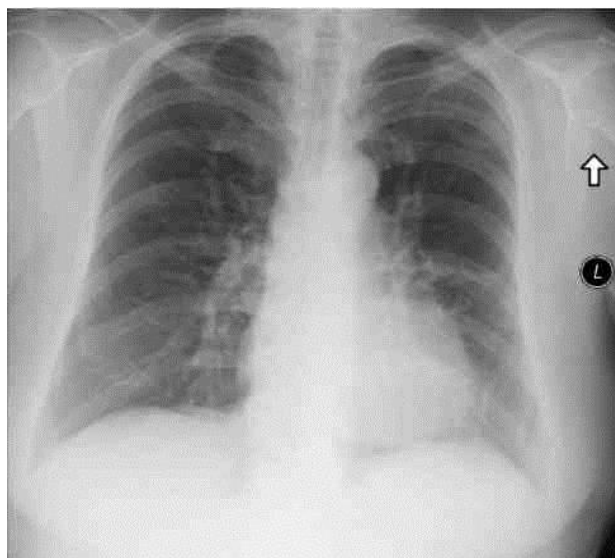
Posteroanterior chest X-ray (August 18, 2014). No consolidations in the lungs, small fibrous changes in the left lung, diaphragmatic retraction due to pleural adhesions.
